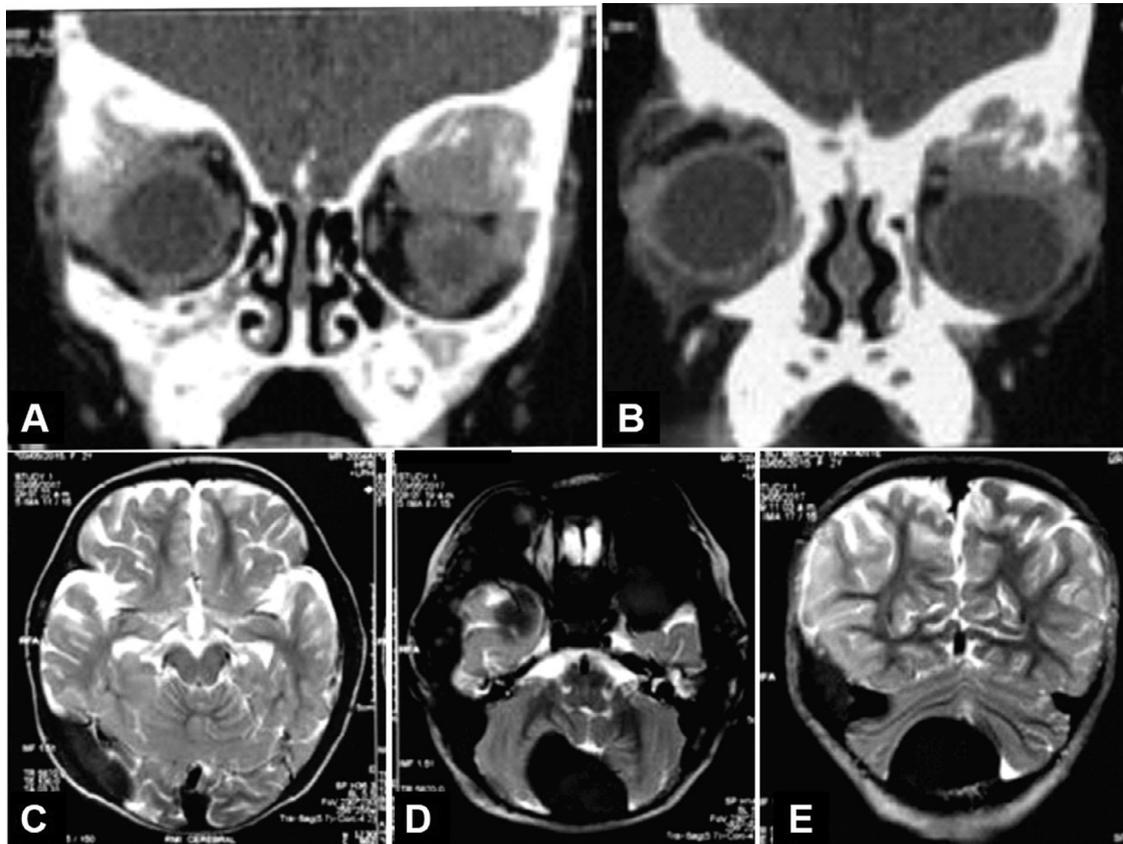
Imaging features. Non-contrast-enhanced, coronal computed tomography (CT) soft tissue window shows 2 masses in the orbits. Focal areas of cortical destruction are observed (A, B). Axial and coronal slices of magnetic resonance imaging (MRI) show multiple, hypointense, space-occupying masses in the right occipital lobe, right temporal lobe, right transverse sinus, left orbit, left temporal lobe, and cerebellum. No destruction of adjacent structures is noted (C, D, & E).
